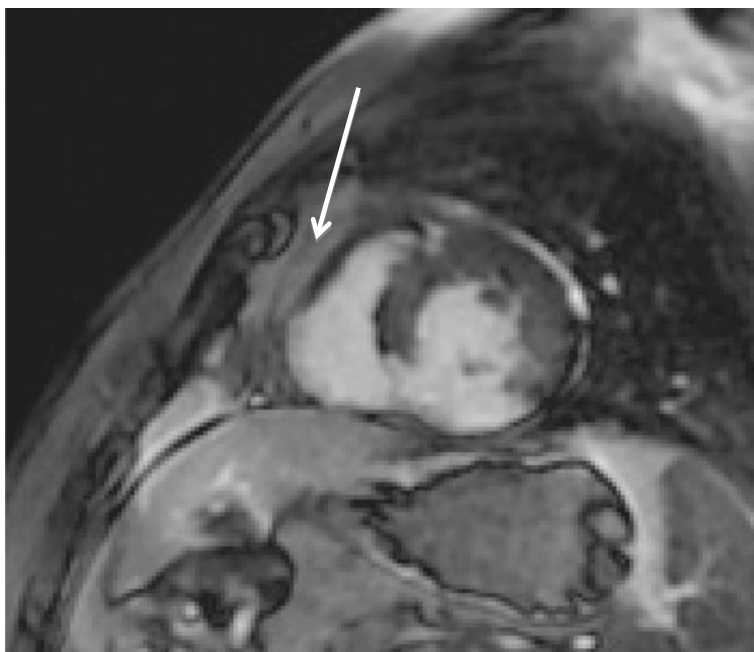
A basal short axis slice from a Cardiac MRI. There is myocardial thinning in the inferoseptal and inferior walls with transmurular delayed enhancement (denoted by the white arrow) as well as thinning of the inferior portion of the RV wall
